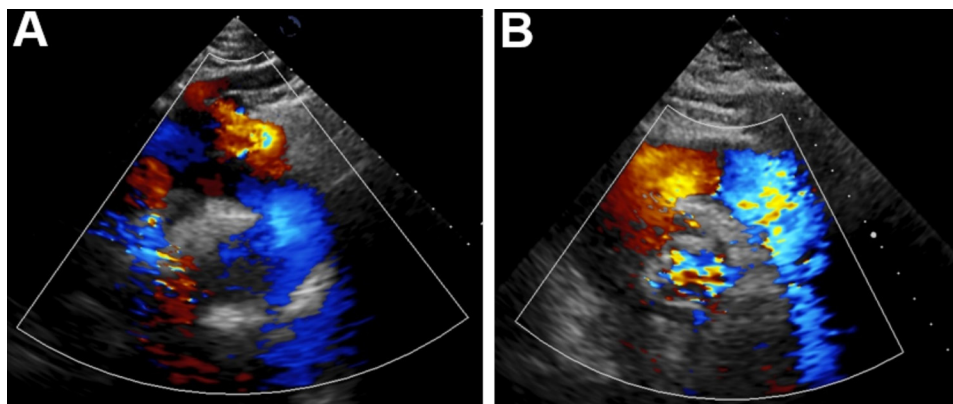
Preoperative and postoperative transesophageal echocardiogram
